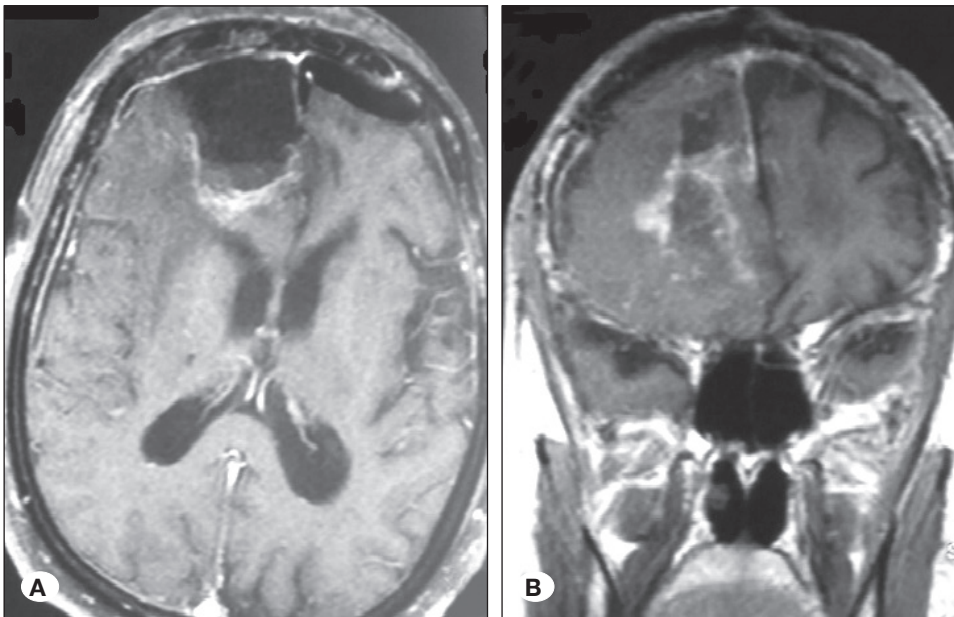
Early postoperative MRI from "Case 3". MRI demonstrating that gross-total resection was performed; A) axial T1W and B) coronal T1W sequences.
